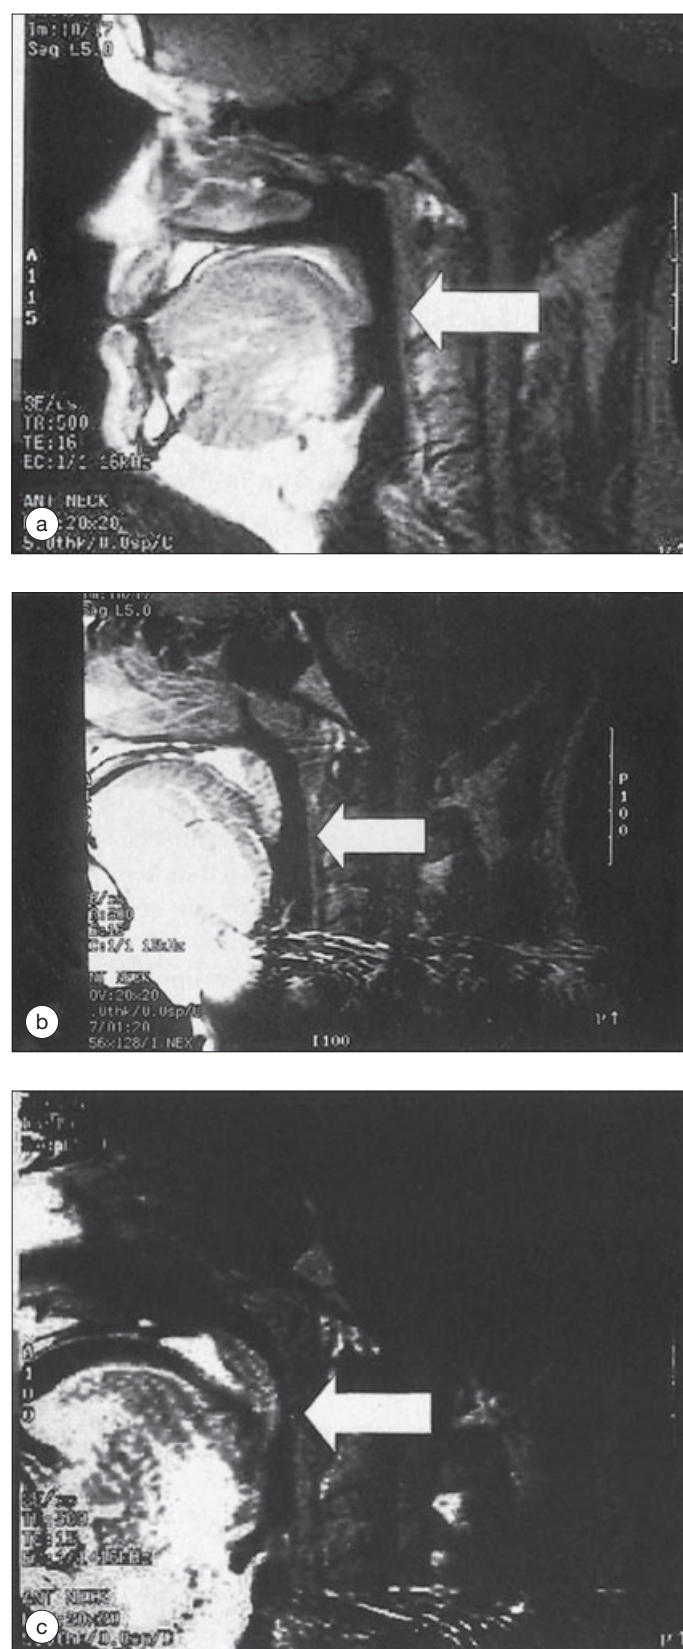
Magnetic resonance images of a healthy volunteer during inspiration while conscious (a), or anesthetized with propofol (b) or ketamine (c). Anterior-posterior diameter of the pharynx at the level of the soft palate is marked by decreased during propofol anesthesia (b) but maintained during ketamine anesthesia (c).
